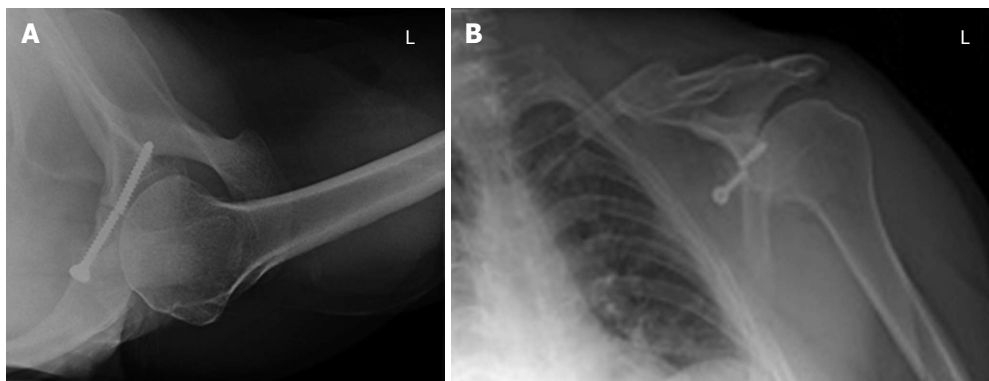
45-year-old gentleman with previous open Latarjet procedure for left shoulder instability. Subsequent non-union of graft and failure of metalwork is seen on the axillary (A) and antero-posterior (B) radiographs.
